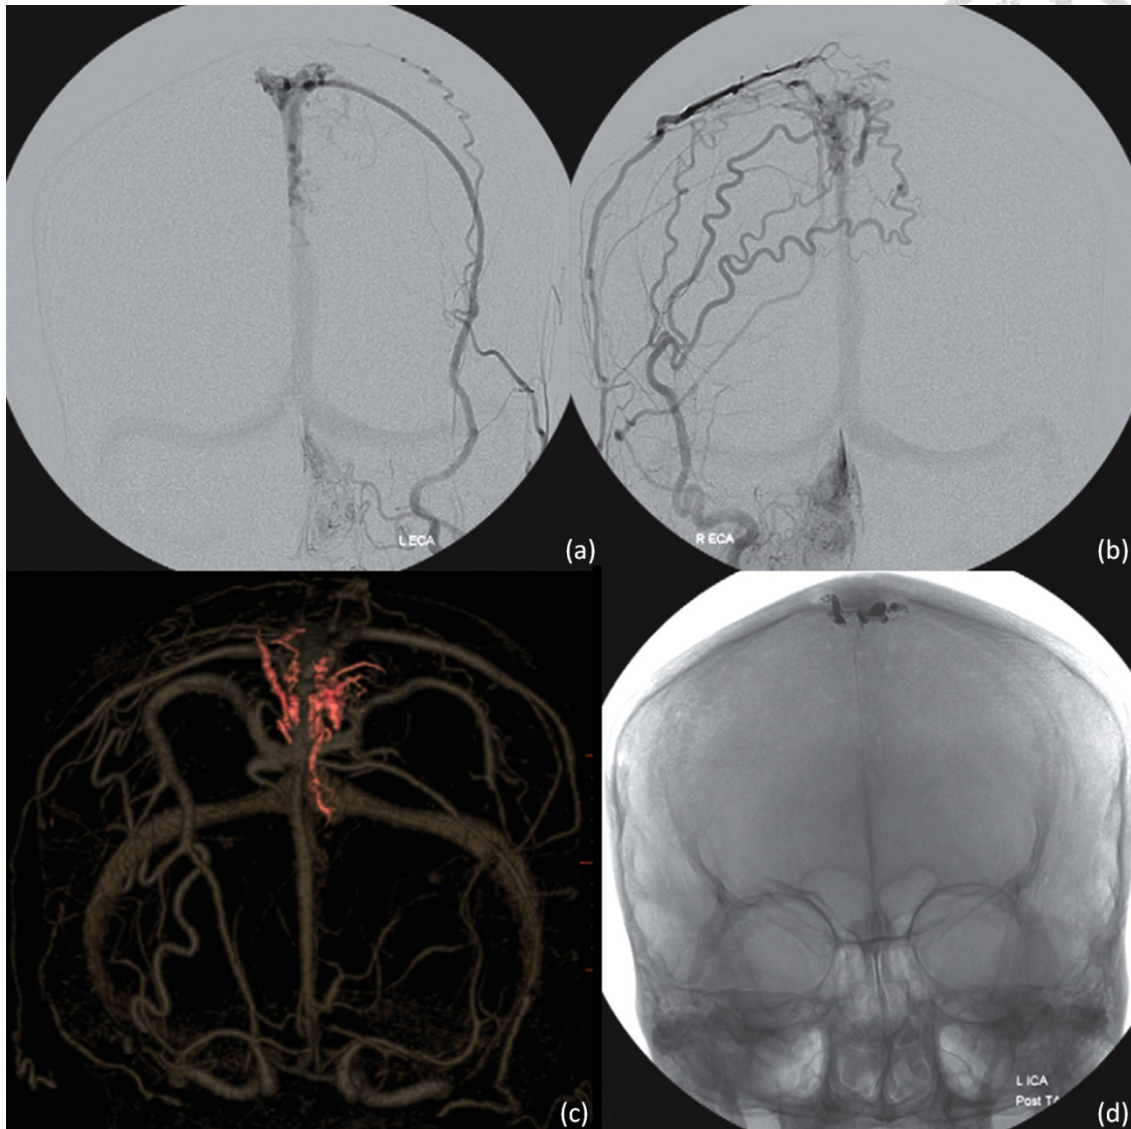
Images in 56-year-old woman with pulsatile tinnitus. (a, b) DSA images of bilateral external carotid arteries demonstrate the fistula, engorged cortical vein, and superior sagittal sinus. The relationship between the fistula and the superior sagittal sinus is not clearly shown. (c) Hybrid CT angiogram obtained with volume rendering depicts the fistula inside the bilateral paramedian posterior frontal bones (red), the engorged cortical drainage vein (red), and patent superior sagittal sinus. After transarterial approach with coils deploying in the venous side of the fistula, complete obliteration of the lesion was achieved. (d) Plain radiograph shows platinum coils inside the bilateral paramedian posterior frontal bones.
